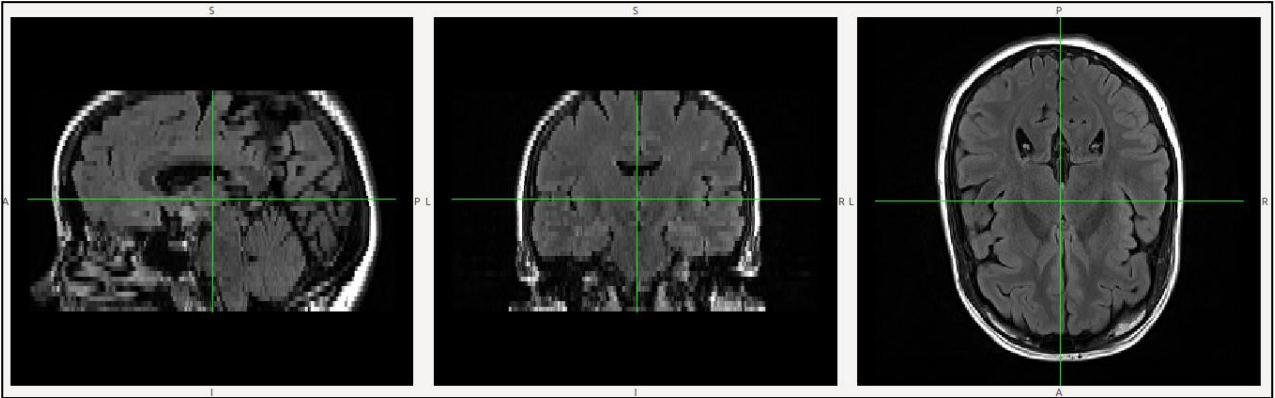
3-Dimensional Fluid Attenuated Inversion Recovery (3D FLAIR) sequence
